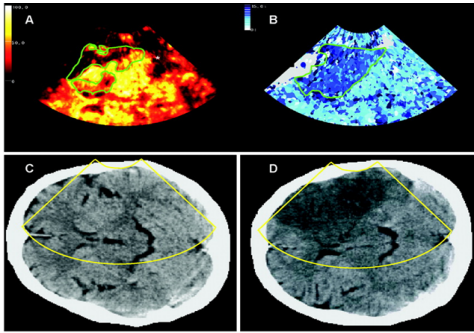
Harmonic imaging ultrasound (top) and cranial computed tomography (CT) (bottom) for comparison [Seidel *et al.*, 2004]. (A) Pixel-wise peak intensity image. (B) Time to peak intensity image. (C) CT scan 3 hours after symptom onset. (D) CT scan 30 hours after symptom onset.
